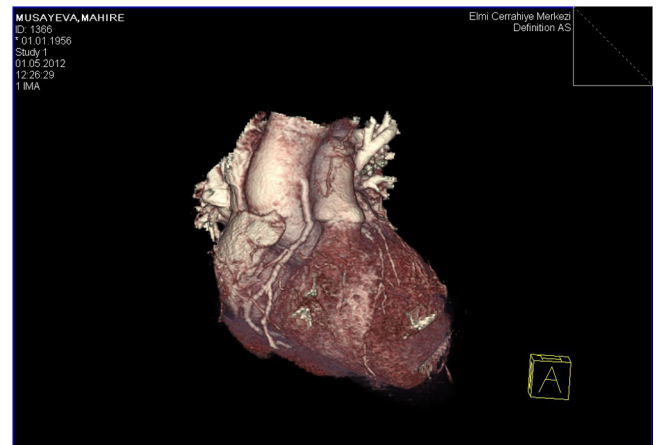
Computed tomography-angiography (64 slice) showing anomalous right coronary artery origin.
